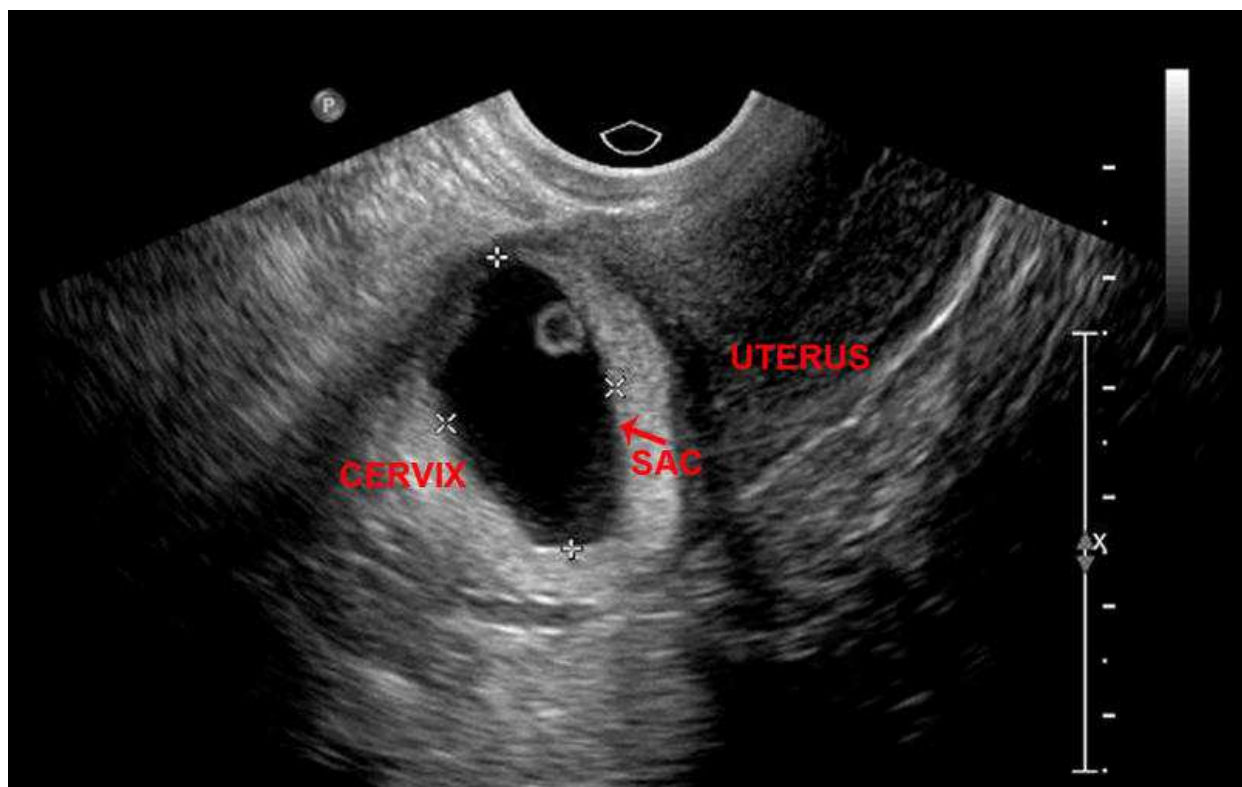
Ultrasound of Cervical pregnancy
